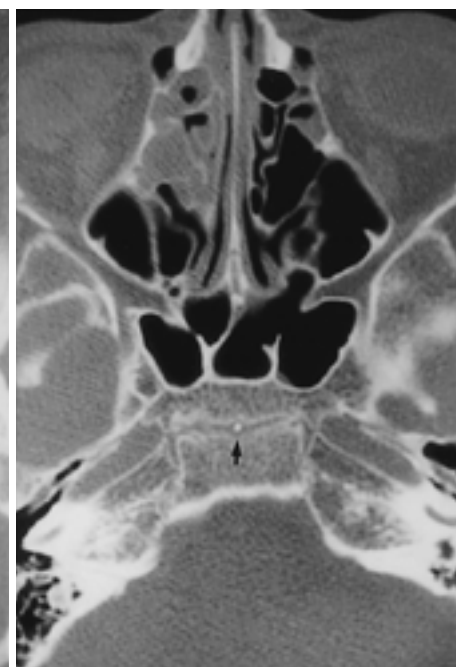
Intralateromedial postsphenoidal pseudoforamen. Axial CT scan in a 2-year-old girl shows unilateral intralateromedial postsphenoidal pseudoforamen(arrow) located in posterior portion of the fused lateromedial postsphenoidal synchondrosis.
